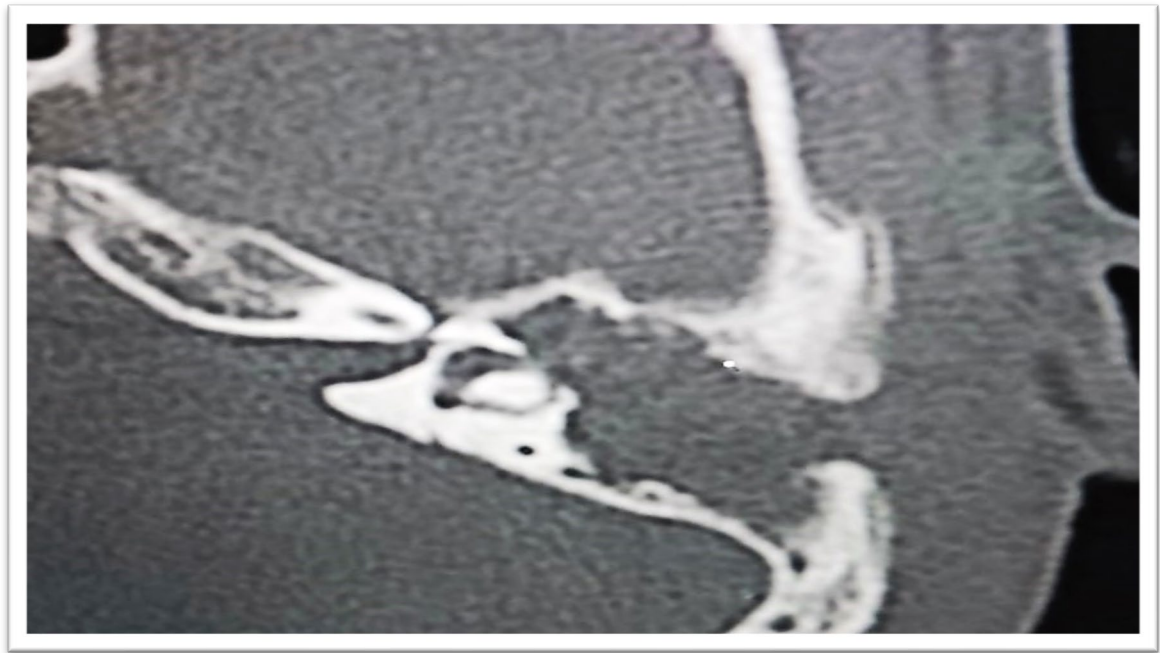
Preoperative CT showing Type II fistula lateral semicircular canal
